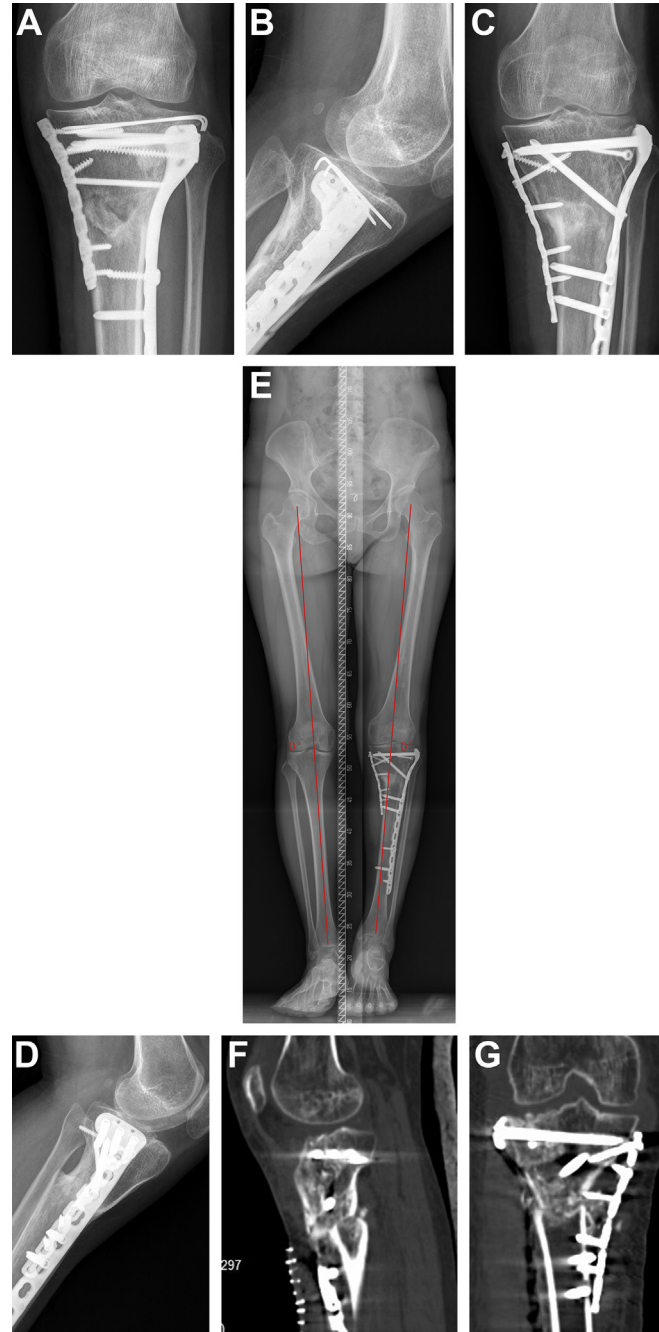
A 52-year-old man. (A, B) Preoperative X-ray showed collapse of the lateral tibial plateau, basically normal alignment, and posterior slope angle. (C–E) X-rays showed that after the internal fixation was removed, the lateral tibial plateau articular surface collapsed about 6 mm, and the alignment valgus was about 8°. (F–H) X-rays and CT scan after the revision operation showed that the fracture healed and the articular surface collapse was reduced.
